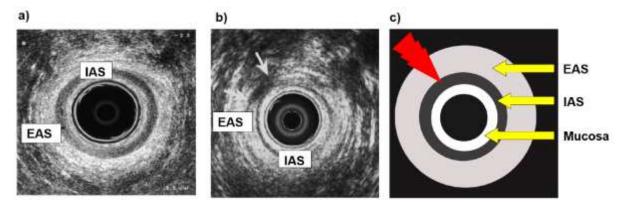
Anal ultrasound showing the anal sphincter muscles in cross-section through the middle anal canal
